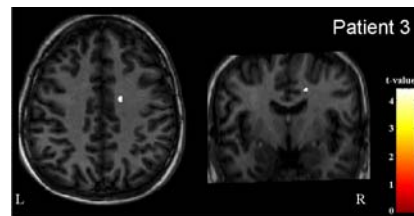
Area showing significant decrease of FA in the white matter of patient 3 in comparison to the collection of normals ($p_u < 0.001$) superimposed on the normalized T1-weighted anatomical image of patient 3 (Talairach-coordinates: 16, -5, 39). L = left; R = right.
